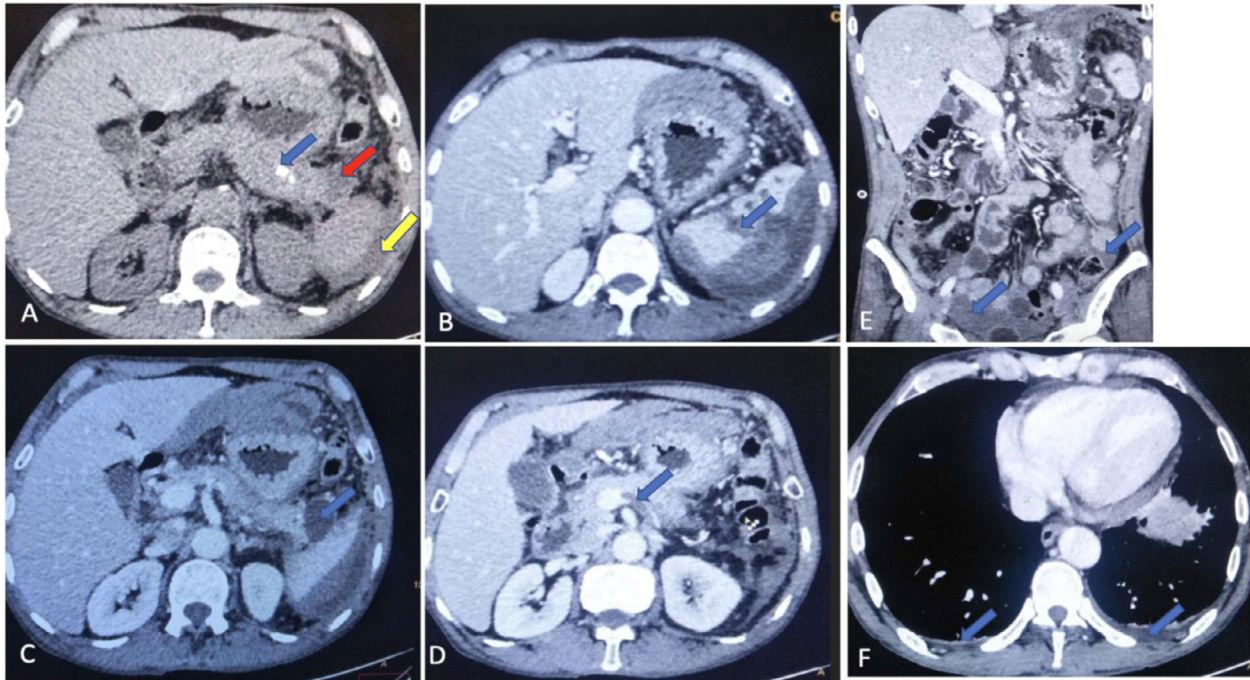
CT images. (A) Noncontrast axial image showing calcification of pancreatic tail (blue arrow) and a well-defined hypodense lesion adjacent to the tail of pancreas (red arrow) with perisplenic collection (yellow arrow). (B-D) Contrast-enhanced axial images showing nonenhancing hypo-attenuating areas in the splenic parenchyma (blue arrow in B), with perisplenic collection of different attenuation, a nonenhancing cystic lesion adjacent to the tail of the pancreas (blue arrow in C) (pseudocyst) and a nonenhancing eccentric filling defect in the splenic vein demonstrating by blue arrow in D (likely a thrombus). (E) Contrast-enhanced coronal image showing mild fluid in peritoneal cavity (blue arrows). (F) Minimal-free fluid in bilateral pleural cavities (blue arrows).
